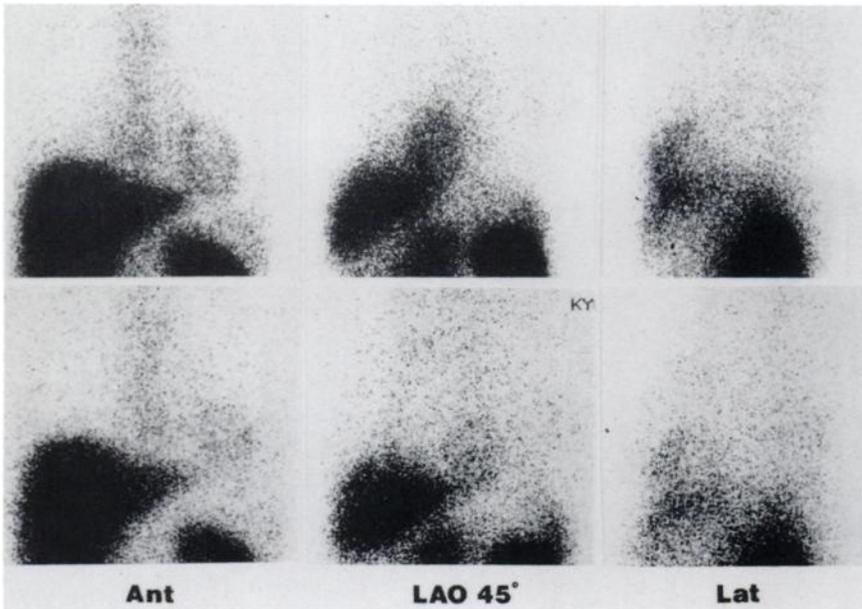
Planar ^{111}In -antimyosin scintigraphic images obtained at 10 days after myocardial infarction (upper images) and 10 mo later (lower images). Definite myocardial uptake is seen in the anterior wall in the first study (HLR, 1.86), and persistent but decreased uptake is seen in the second (HLR, 1.49). Ant = anterior view; LAO 45 = left anterior oblique 45° view and Lat = lateral view.
